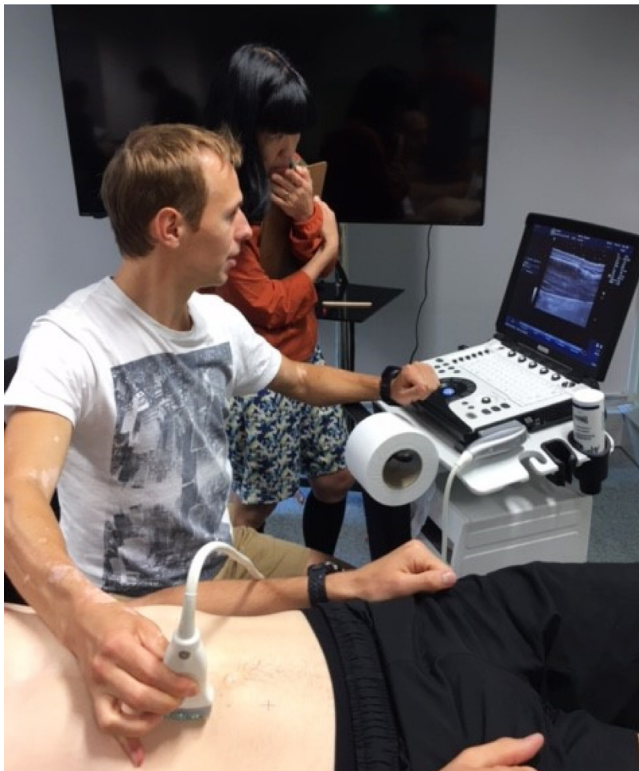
Dr. Andrius Ramonas (New Zealand) and Dr. Kazuko Ishikawa-Takata (Japan) using an ultrasound to capture an image at the UA site during an ultrasound body composition training course at the J.E. Lindsay Carter Kinanthropometry Clinic in Auckland, New Zealand.
